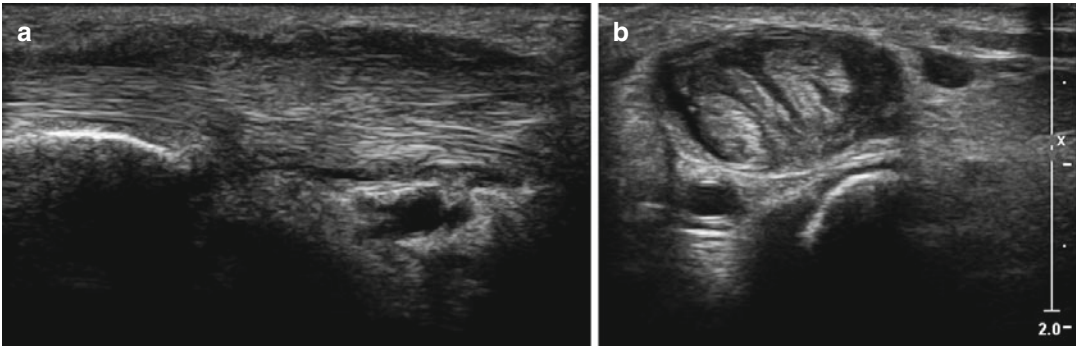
De Quervain's syndrome. Ultrasound scans in the longitudinal (a) and axial (b) planes.
